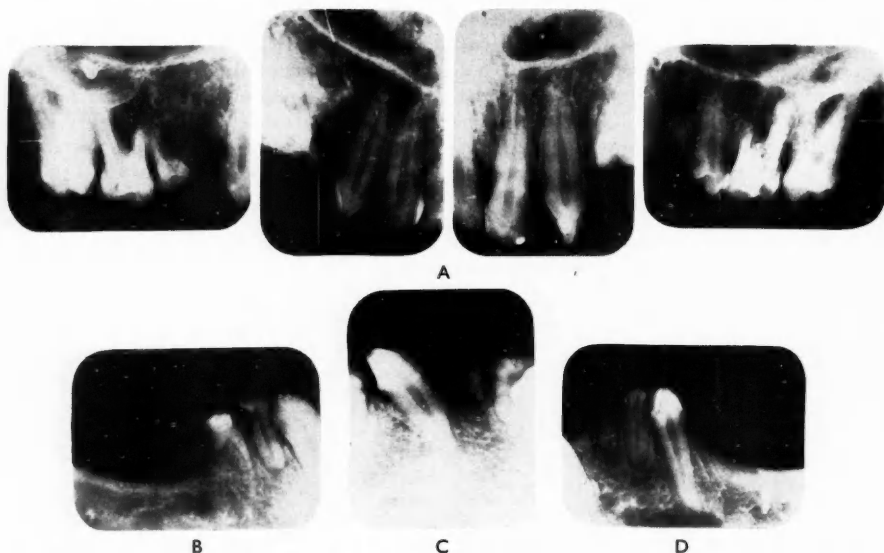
Radiographs of the dentition in a case of partial anodontia. Note at A the absence of $\overline{2}2$ and the conical form of $\overline{3}3$; in B and D the absence of several permanent teeth particularly those which normally succeed $\overline{D}AB$; in C the angulation of $\overline{3}$.
